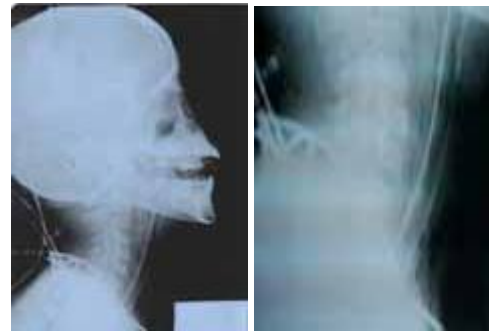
(a/b). Subcutaneous emphysema in front of neck in lateral cervical x-ray after intubation
